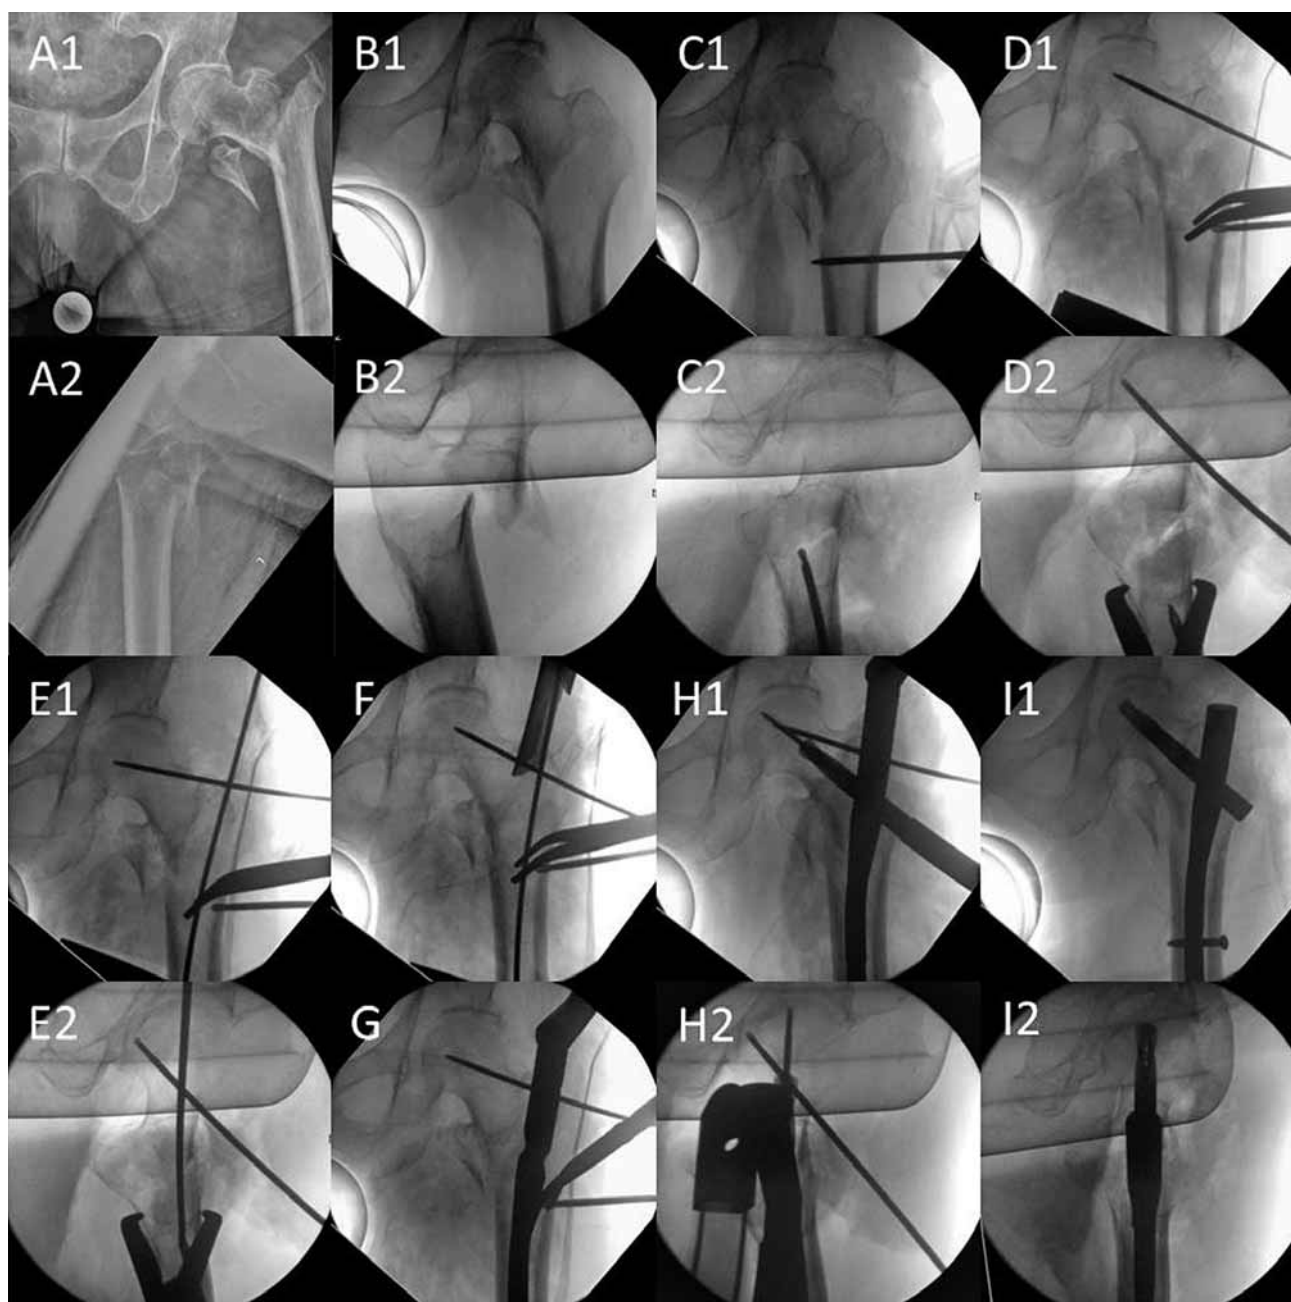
Case presentation of an 89-year-old female patient. The stepwise escalation of reduction techniques to master reduction and stabilisation of this isolated highly unstable trochanteric fracture is demonstrated. A1 and A2 – preoperative AP and lateral view. AO 31-A2 fracture. B1 and B2 – AP and lateral view. Closed reduction techniques on the traction table failed to achieve a good result. Remaining dorsal displacement of the shaft fragment. C1 and C2 – AP and lateral view. The distal main fragment was reduced with a percutaneous Schanz screw and additional support was provided by a height-adjustable instrument table, placed underneath the shaft fragment. However, reduction could not be maintained in this highly unstable situation. When the guide wire was inserted through the comminuted tip of the greater trochanter, external rotation of the head-neck fragment occurred. Stepwise release of traction also failed to „lock“ the fracture. D1 and D2 – AP and lateral view. A limited open approach was performed and a K-wire was drilled into the head-neck fragment from anterolateral, avoiding the distal fragments. The Schwanz screw was withdrawn to the lateral cortex and a reduction clamp applied to maintain reduction. Thus, control of the proximal fragment was gained without interfering with following guide wire and nail insertion. E1 and E2 – AP and lateral view. The guide wire was inserted while the K-wire prevented external rotation/displacement of the head-neck fragment. F – AP view. Careful opening of the trochanteric bone with a cannulated cutter. The medial cortex was engaged first to avoid lateral migration of the cutter. G – AP view. Placement of a short proximal femur nail antirotation (PFNA; 200/10mm, 1250) without losing reduction. H1 and H2 – AP and lateral view. Placement of the guide wire centrally into the femoral head, followed by insertion of the blade. Before the blade touched the joy stick in the femur head, the K-wire was retrieved just enough to allow passage of the blade. Once the blade was in its final position, the K wire was removed. I1 and I2 – AP and lateral view. Final X-rays after insertion of the distal locking screw demonstrated an adequate fracture reduction and correct position of the implants. Full weight bearing was allowed postoperatively.
